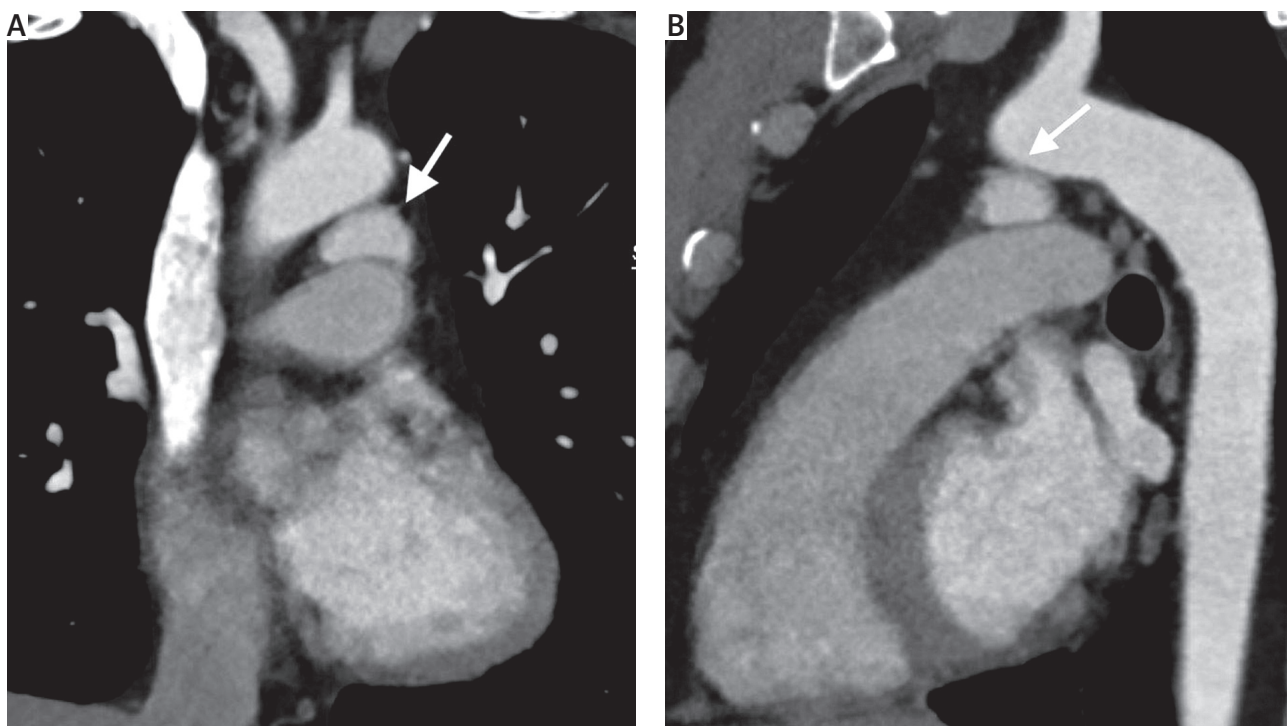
Contrast-enhanced chest CT, multiplanar reconstruction (MPR): A – coronal view, B – sagittal view. Images show a hypervascular tumor in the aortopulmonary window (arrows)
